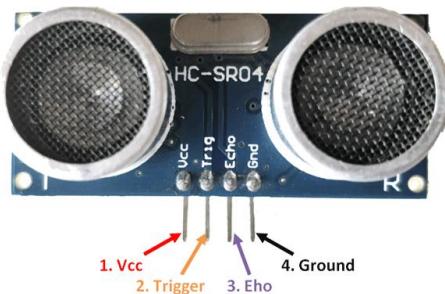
Ultrasonic Sensor
